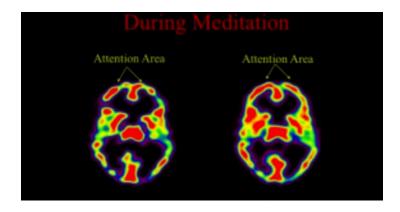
Side by side MRI comparison of brain during meditation with attentional area on the frontal lobe (Newberg et al., 2006)
